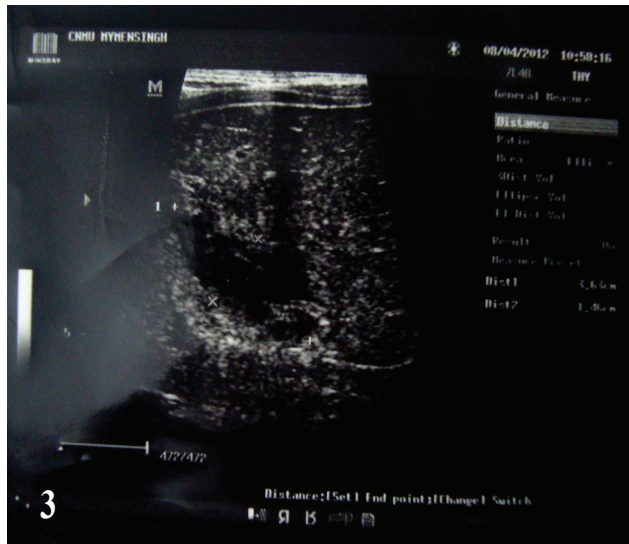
Ultrasound image of a 40 years male demonstrating lung splenic rupture with hematoma formation.
